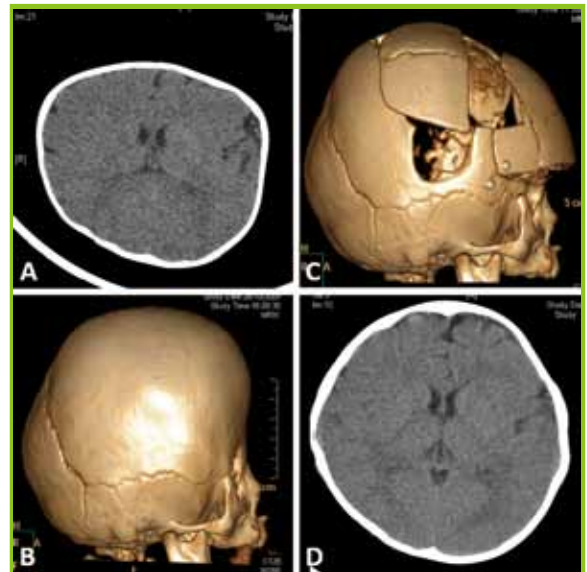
A patient with bilateral coronal suture synostosis presented to us with severe brachycephaly at 7-month-old. A & B: Pre-operative CT scan images showing markedly shortened anterior-posterior (AP) diameter of the skull, and "flattened" frontal lobes. C: CT at 3-week after reconstruction showing corrected AP diameter of the head, and the arrangement of the bone flaps as at surgery. D: CT at 1-year after operation showing the re-expanded frontal lobes.
